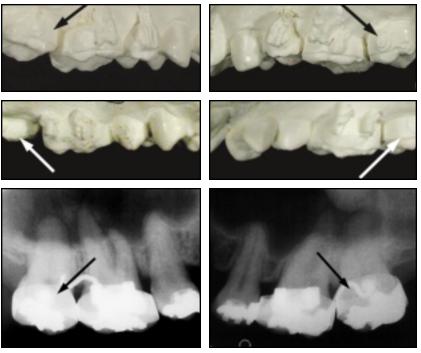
Case 2. Intrusion of both upper second molars in two months (arrows). Radiographs show no root resorption, and marginal alveolar bone levels appear to have approximated cementoenamel junctions.
